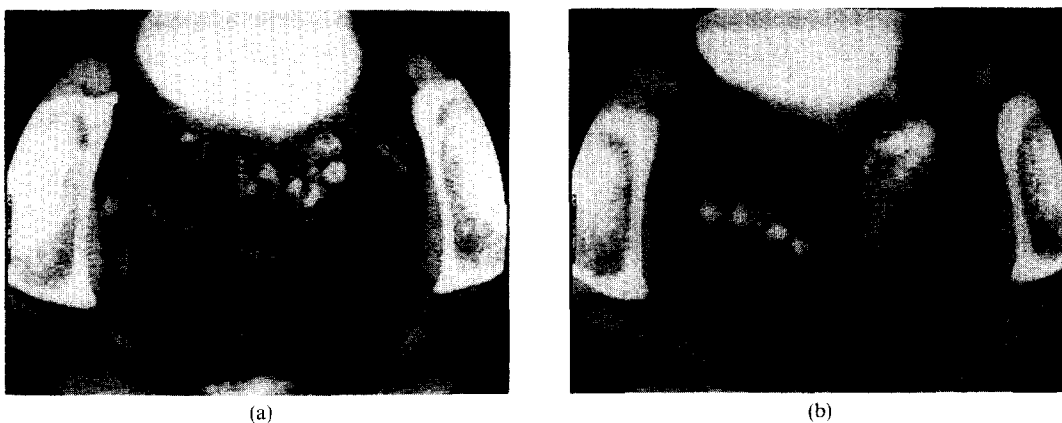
Case 4; sigmoid diverticulitis is shown by air contrast CT (a,b). Diverticuli (arrows) deeply penetrate the thick inflamed sigmoid wall.
